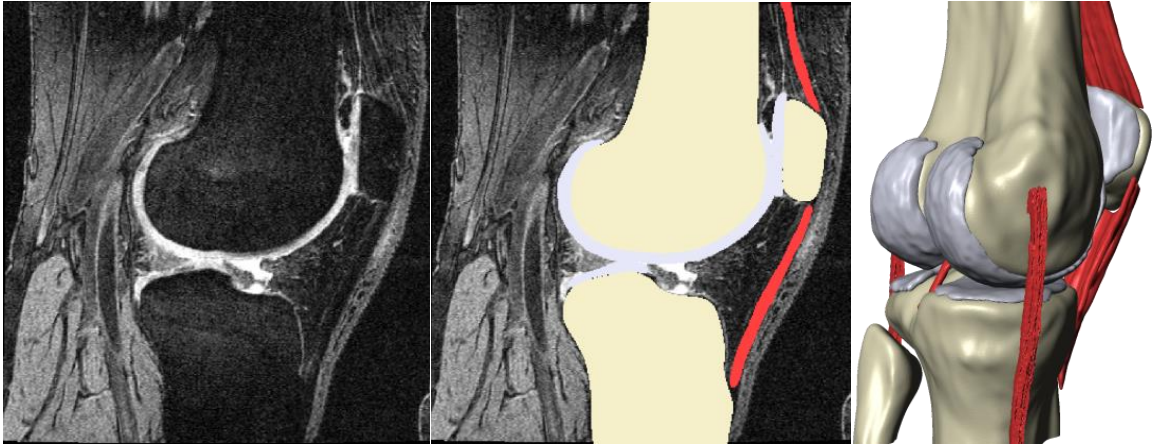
Geometry segmentation process; (a) sagittal MRI scan of human knee, (b) bone, cartilage, and soft tissue manually segmented, (c) knee joint extracted in 3-D representation
